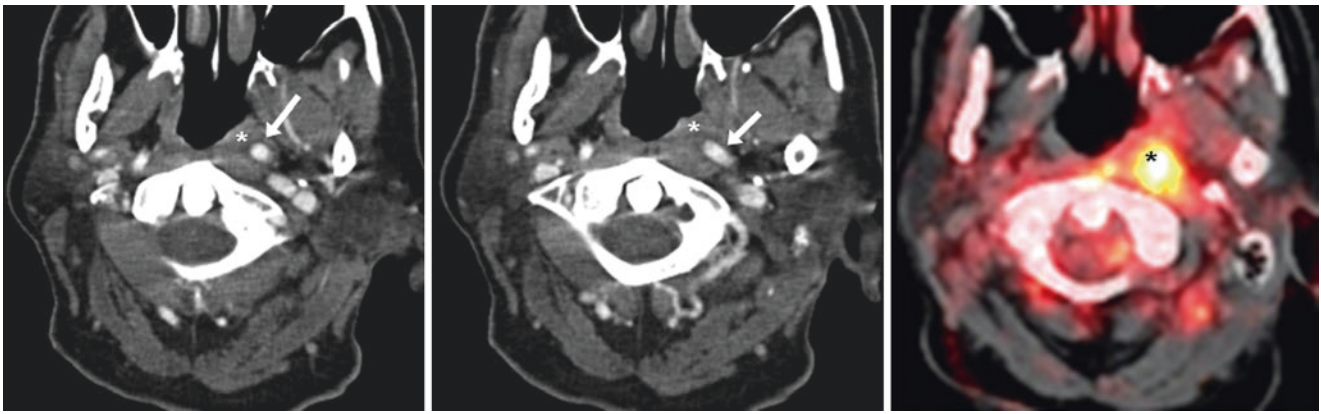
Comparison case of mass and retropharyngeal ICA. A 61-year-old showed a left nasopharyngeal mass (*asterisks*) and a retropharyngeal ICA (*arrows*) on routine contrast-enhanced CT (*left and middle*). On a fused ^{18}F FDG PET-CT (*right*), the mass had an elevated standardized uptake value (SUV) greater than 7, which was suspicious and later confirmed to be malignancy
